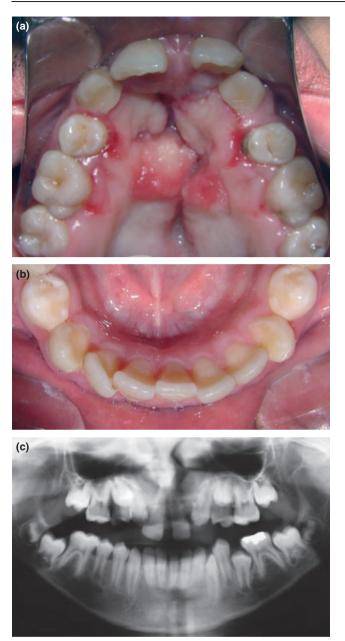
Clinical (a and b) and radiographic (c) aspect of bilateral agenesis of maxillary lateral incisors and second premolars and incisiform mandibular anterior supernumerary tooth in patient with G/BBB syndrome
